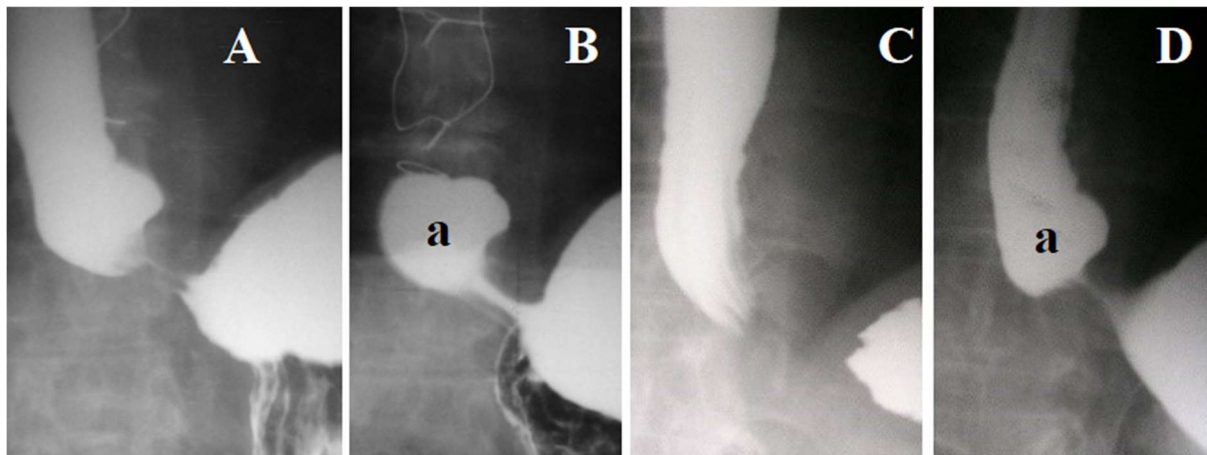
EGJ radiographs of patients with GERD during abdominal compression. (A-B) phrenic ampulla (a) injects a bolus into the stomach through an open LES. This means that the pressure in it is higher than in the stomach. Such a high pressure could be created due to the contraction of the functional sphincter, the contraction of which blocked the lumen of the esophagus above the ampulla. I have named this sphincter the proximal sphincter (PS). The length of the LES between the ampulla and the stomach is about 1 cm (normally about 3.6 cm), since the suprathrenic (0.5 cm) and abdominal part (2.1 cm) of it opened, unable to withstand pressure. (C-D) An example of the formation of "shoulders" in the distal esophagus and in the stomach, which face each other during the opening of the LES between them.
